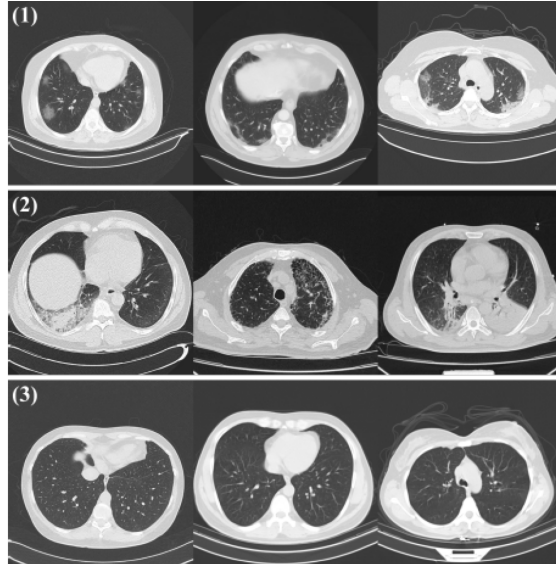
Sample CT images from the COVIDx CT dataset. From top to bottom, the images in (1) represent coronavirus pneumonia due to SARS-CoV-2 infection (NCP), (2) are common pneumonia (CP), and (3) are healthy lungs. Images are courtesy of [10].
